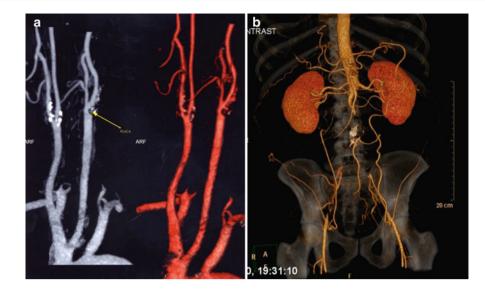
(a) CT-angio of the supra-aortic trunks (calcified carotid plaques). (b) CT-angio of the abdominal vessels (aortic thrombosis)
